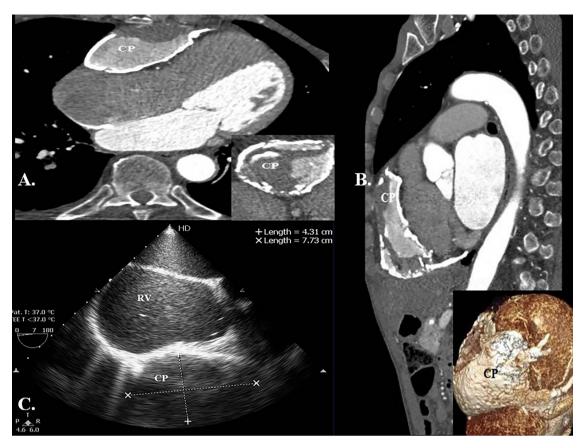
(A) Contrast enhanced angio CT demonstrating an anterior mass obstructing the right ventricular inflow tract. (B) The mass has two calcified layer and some fluid collection extending from the diaphragmatic aspect to the right ventricular infundibulum. (C) Preoperative echocardiography demonstrating the anterior localized mass. Legend: CP = Constrictive pericarditis, RV-Right ventricle.
